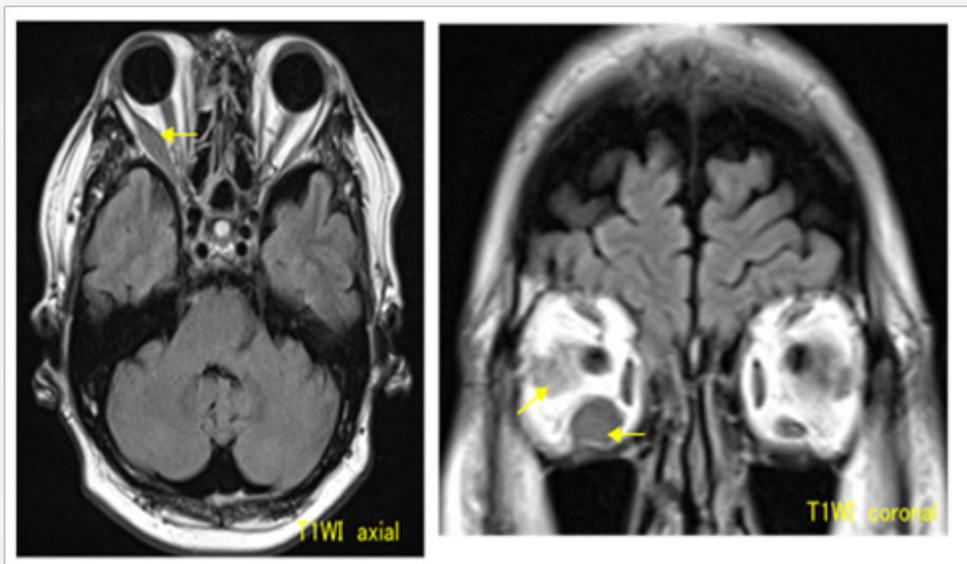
Orbital MRI. MRI showed swelling of the right rectus and inferior rectus muscles of the right eye.
